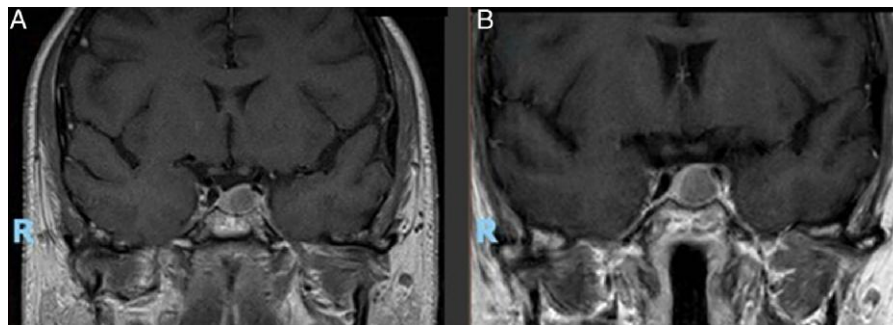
(A) Baseline sagittal, post-contrast T1-weighted MRI demonstrating an 8.6 mm presumed NFPA in the left side of the sella. (B) Sagittal, post-contrast T1-weighted MRI demonstrating enlargement of the tumour 4 years after the baseline imaging (macroadenoma, 12 mm).
